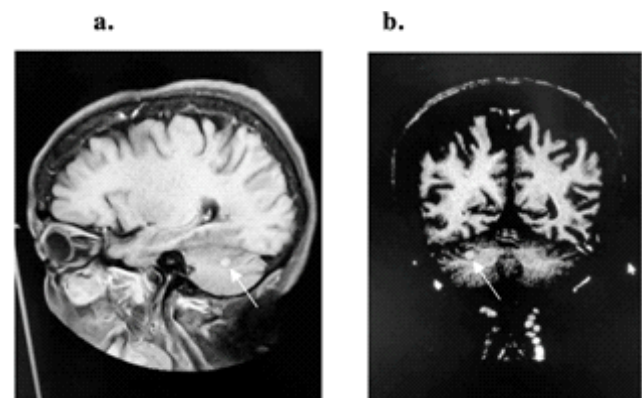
Brain magnetic resonance image before pembrolizumab treatment. Sagittal view measuring 0.6 x 0.7 x 0.5 cm (a) and coronal view (b).
